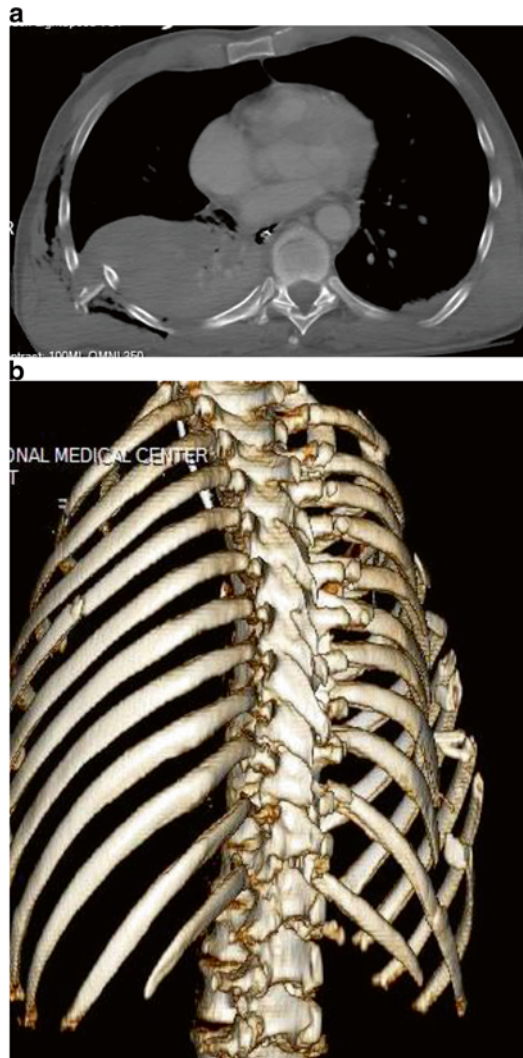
A CT scan (a) demonstrates severe displacement of multiple posterior rib fractures with significant underlying soft tissue injury including hemothorax and pulmonary injury. A 3D CT scan (b) confirms the injury
